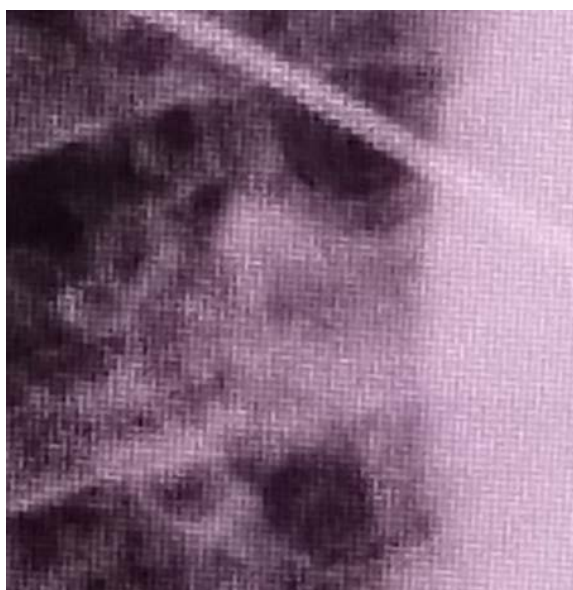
Close cut view of right upper central lung field (AP view) Chest Xray.
